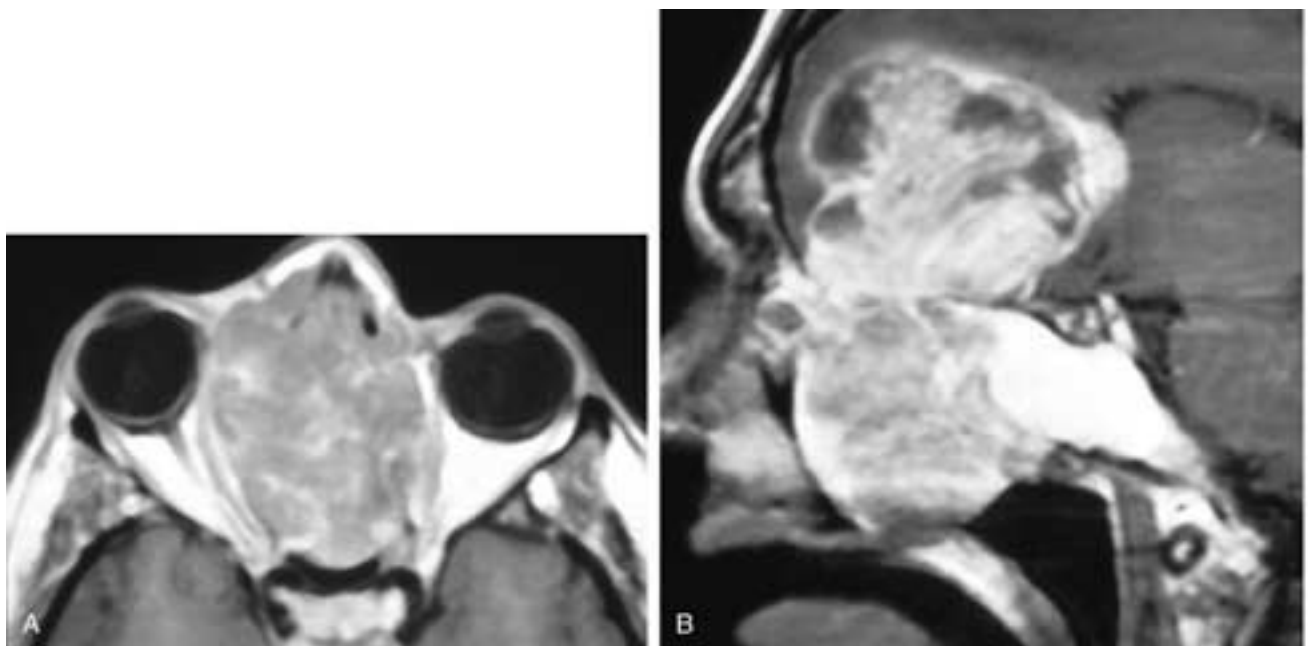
Axial (A) and sagittal (B) T1-weighted, contrast-enhanced MR images show an enhancing mass in the ethmoids and nasal fossa. The mass has extended into the anterior cranial fossa, and several small cystic areas are seen within the intracranial portion of the tumor. The mass has also extended into both orbits, and the sphenoid sinus is obstructed. This patient had an olfactory neuroblastoma.
